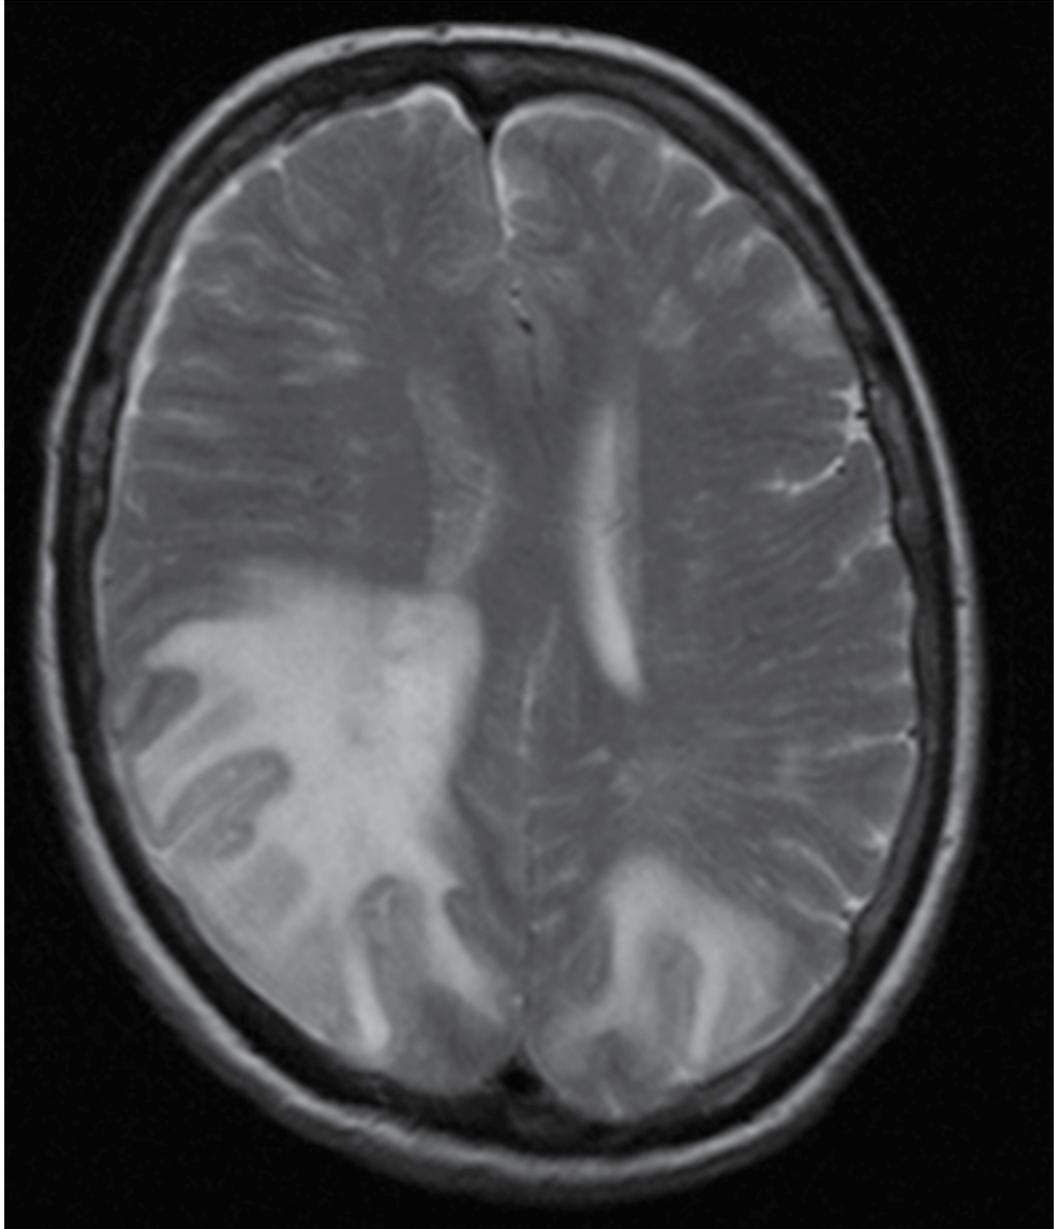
Brain MRI in 72-year-old woman performed in June 2009 reveals extensive white matter lesion in the right parietal and occipital lobe, splenium corpus callosum and left occipital lobe. Figure 1a - transversal MRI section, hyperintense lesion on T2 - weighted image.
